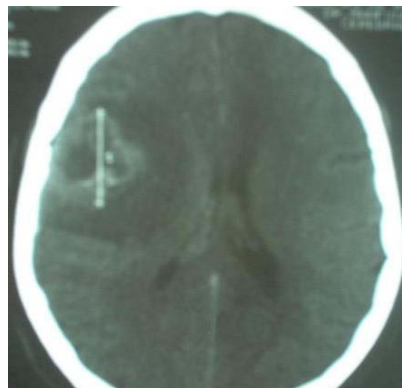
CT scan: A right parietal mass with heterogeneous enhancement after contrast: Glioblastoma multiforme
